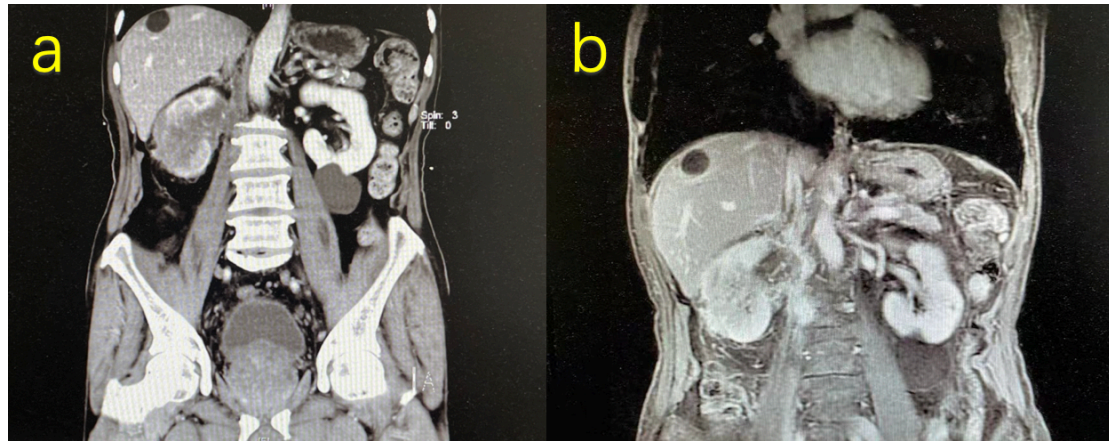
a) The CT image of Patient 1. b) The MRI image of Patient 1.
